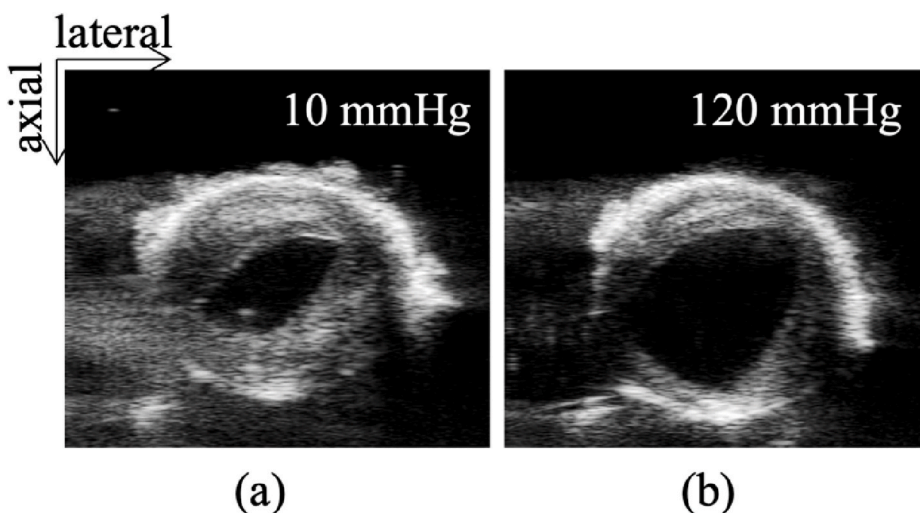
B-mode ultrasound images of a carotid cross section for at 10 mmHg (a) and 120 mmHg (b) pressures.
